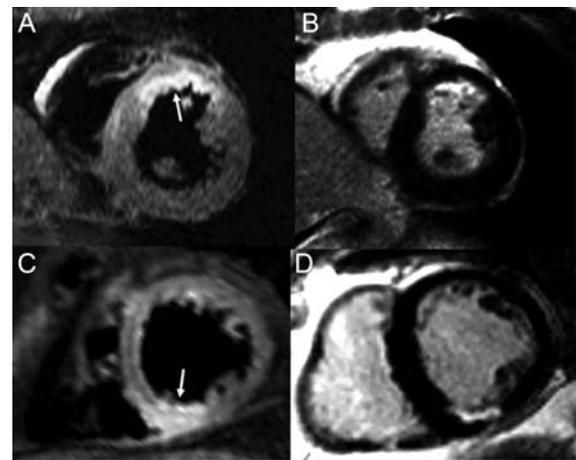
Relationship between infarct location and size. T2-weighted (A and C) and late post-contrast (B and D) images depicting, respectively, infarct-related myocardial oedema (arrows) and late-gadolinium enhancement in a patient with acute anterior (A and B) myocardial infarction and in one with acute inferior myocardial infarction (C and D). Although the myocardial salvage index is closely similar in the two patients (0.61 vs. 0.62), the extent of area at risk and myocardial infarction size are larger in the patient with anterior myocardial infarction (23 vs. 13% of left ventricle for area at risk; 9 vs. 5% of left ventricle for myocardial infarction size).
